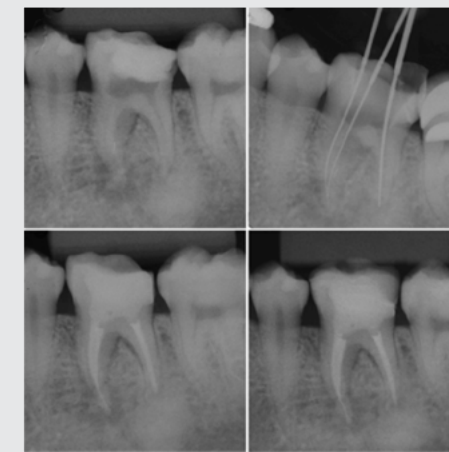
X-ray images of endodontics—upper left, pre-operative image; upper right, working length; lower left, obturation and build-up with Core-Flo DC Lite; lower right, lithium disilicate in place, Case finished.
